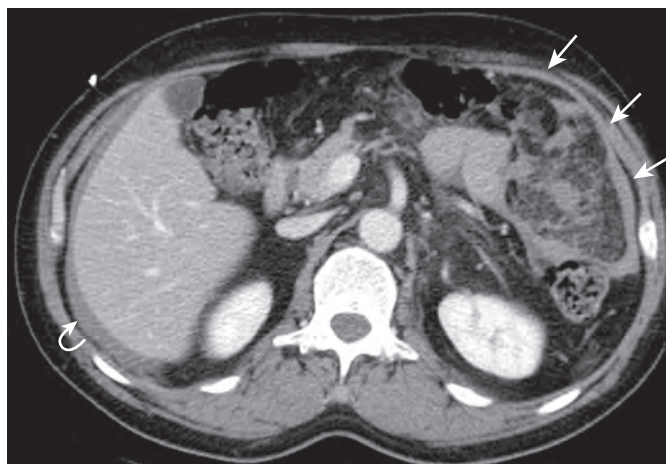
Omental laceration. A 56-year-old is evaluated after a motorcycle accident. Contrast-enhanced CT of the abdomen and pelvis revealed hemorrhage and thickening in the region of the omentum in the left upper quadrant (straight arrows). This hemorrhage extended to the splenic flexure of the colon. Additional hemorrhage was identified surrounding the liver (curved arrow). The patient was taken emergently to exploratory laparotomy, which revealed an omental laceration and a partial-thickness tear of the colon at the level of the splenic flexure.
